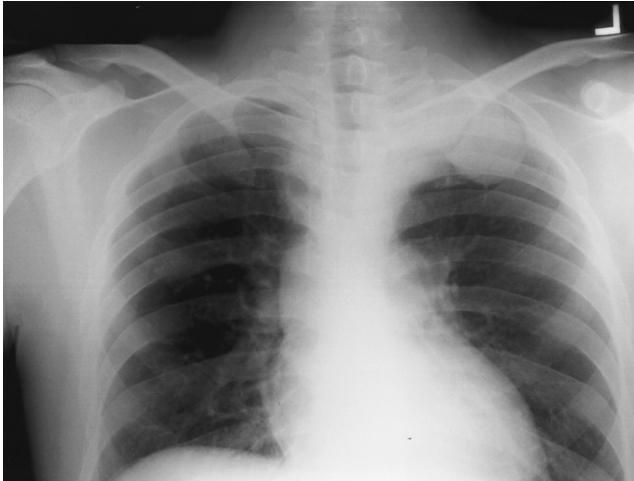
A chest radiograph shows a superior mediastinal mass.
